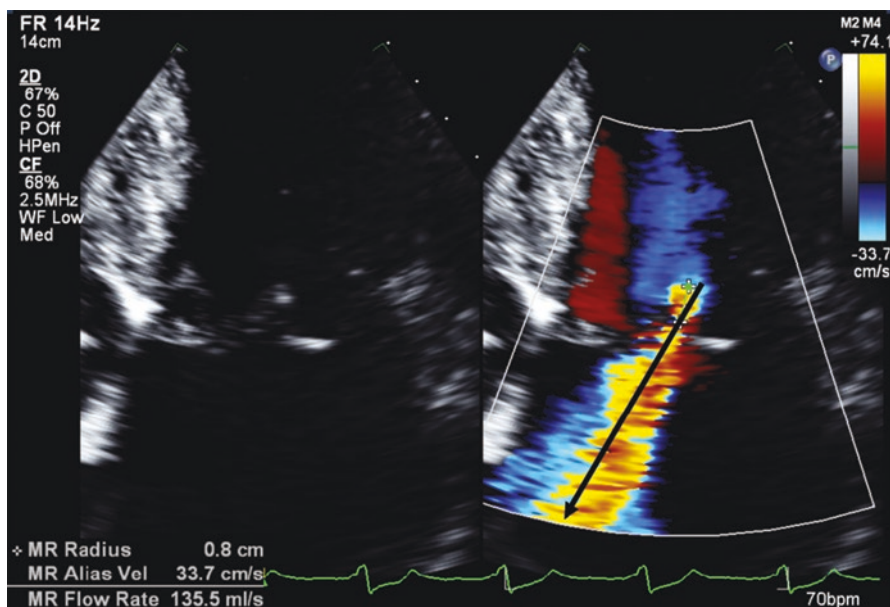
Colour-flow Doppler two-dimensional transthoracic echocardiography in patient with mitral valve prolapse with no flow constriction of the regurgitant jet—the black arrow shows alignment of the three components of the regurgitant jet
